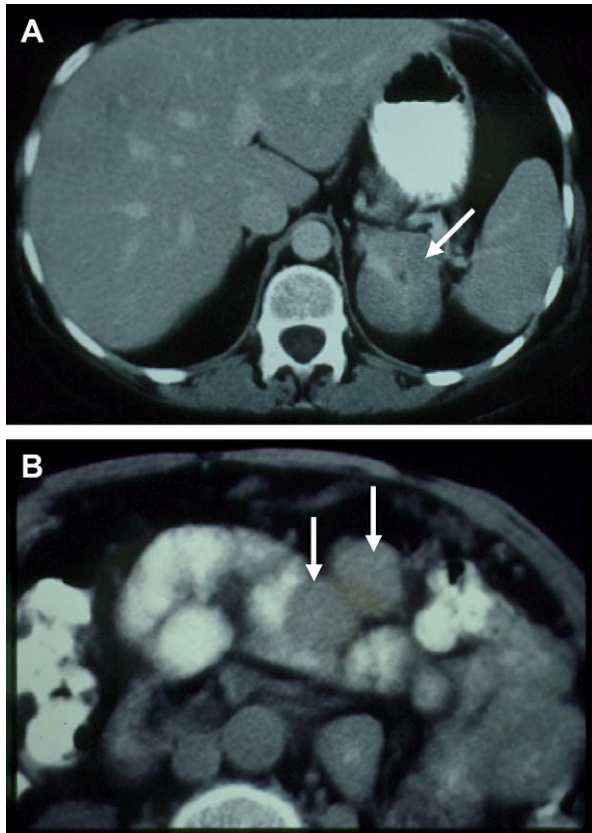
Abdominal CT images of a 43-year-old woman with ACC. (Table III, patient 1). The patient presented with Cushing's syndrome and a 6-cm left adrenal mass (A, arrow). A laparoscopic left adrenalectomy was performed. Cushing's syndrome recurred 7 months post-operatively. Repeat CT documented the presence of multiple intraperitoneal recurrences (B, arrows).
